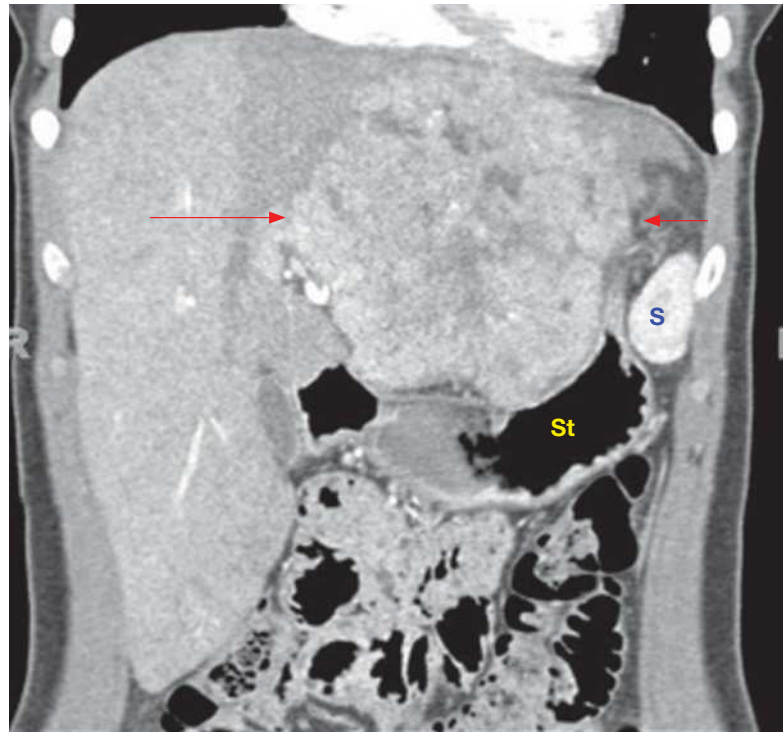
Hepatocellular carcinoma. Coronal reformation from a contrast-enhanced CT shows a large HCC in the left hepatic lobe (*arrows*). St, stomach; S, spleen. (Reproduced with permission from USMLE-Rx.com.)
